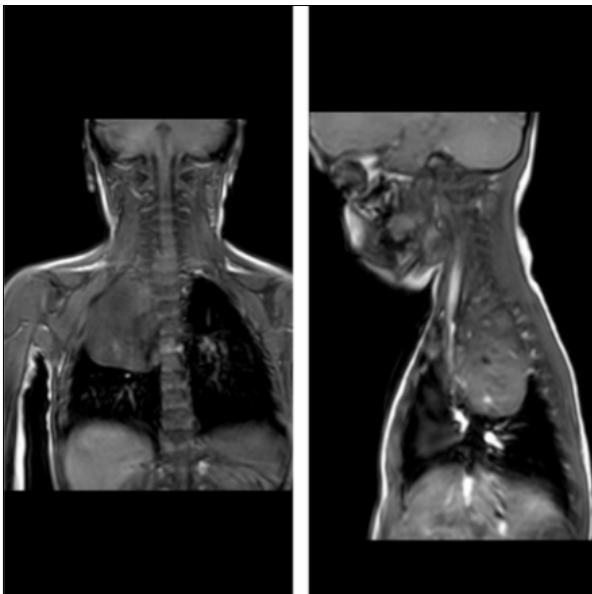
Magnetic resonance imaging sections of the mass located in the posterior mediastinum.
